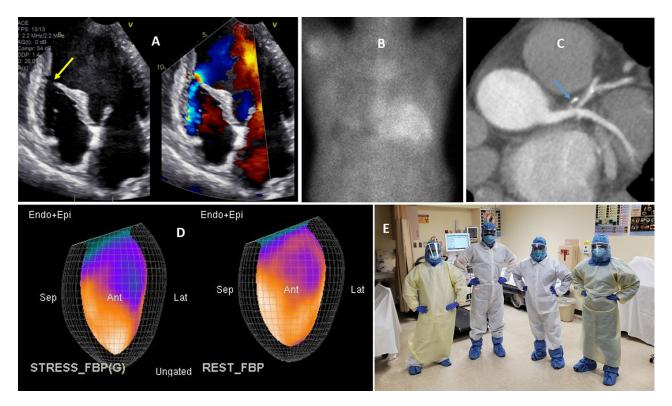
Potpourri of cardiovascular disease in the era of COVID-19 pandemic. (A) Echocardiogram from a 65-year-old COVID (-) patient who took the stay at home order to heart. Patient presented with heart failure, many days after experiencing anginal symptoms. Ventricular septal defect (yellow arrow) developed as a complication of ST-elevation myocardial infarction, requiring open heart surgery. (B) Markedly positive Tc-99m pyrophosphate study in a COVID (-) outpatient with heart failure, being treated with standard heart failure therapy. Patient symptomatically improved after appropriate medical changes were made and hospital admission was avoided. (C) Cardiac computed tomography (CT) angiography, with retrospective gating, from a 60-year-old COVID (+) patient who presented with atypical chest pain, new LV dysfunction (on point of care echocardiogram) and previously noted mild coronary artery calcium on chest CT done for pulmonary embolism. A large, lipid rich (vulnerable plaque; blue arrow) resulting in distal left main and ostial LAD stenosis was diagnosed along with an EF of 24% and LAD wall motion abnormalities. (D) Rest/stress myocardial perfusion from a COVID (+) patient presenting with chest pain, and a remote history of CAD. Diagnosis of modest ischemia in the diagonal distribution guided escalation of antianginal therapy. (E) Cardiac stress laboratory personnel, at Stroger Hospital of Cook County, in full personal protective equipment gear, ready to perform an appropriate stress test in a COVID (+) inpatient.
